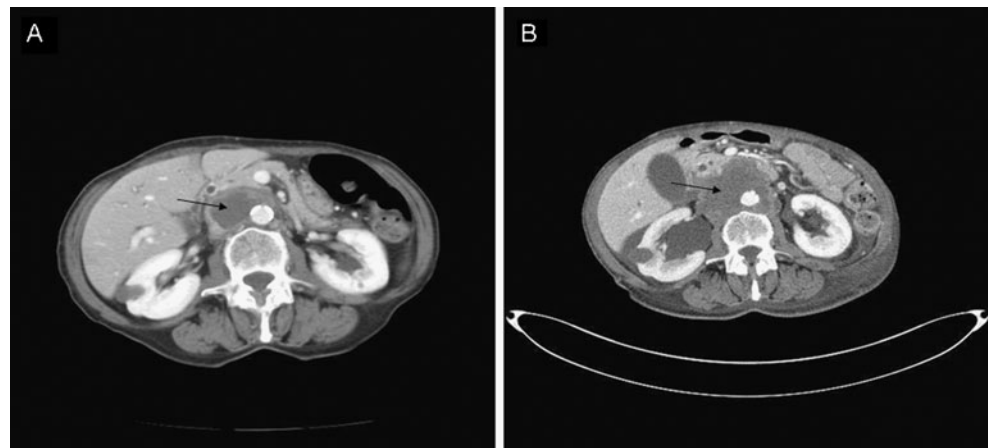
CT images. a. After 3 months (six cycles) of adjuvant chemotherapy, a CT scan revealed a retroperitoneal mass 4 cm in diameter, extensively necrotic and infiltrating the head of the pancreas. b. Two months later, after four cycles of chemotherapy for metastatic disease, a new CT scan showed an increase in the size of the retroperitoneal mass up to 78×55 mm
